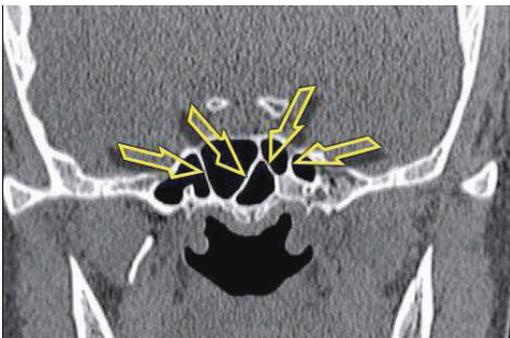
CT scan of the paranasal sinuses, frontal plane. Total number of septa — 4, total number of antra in the sphenoid sinuses — 5 (4/5).
